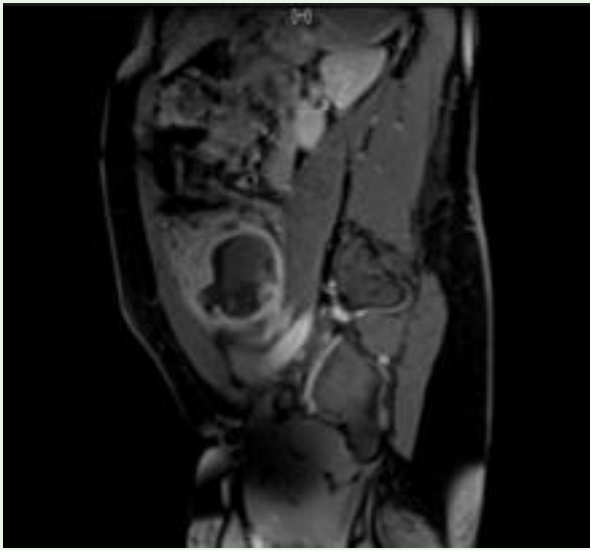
Abdominal and Pelvic MRI of the Pyomyoma, demonstrating heterogeneity within the mass, presence of an enhancing peripheral rim, and a partial capsular rupture at the anterior aspect.
